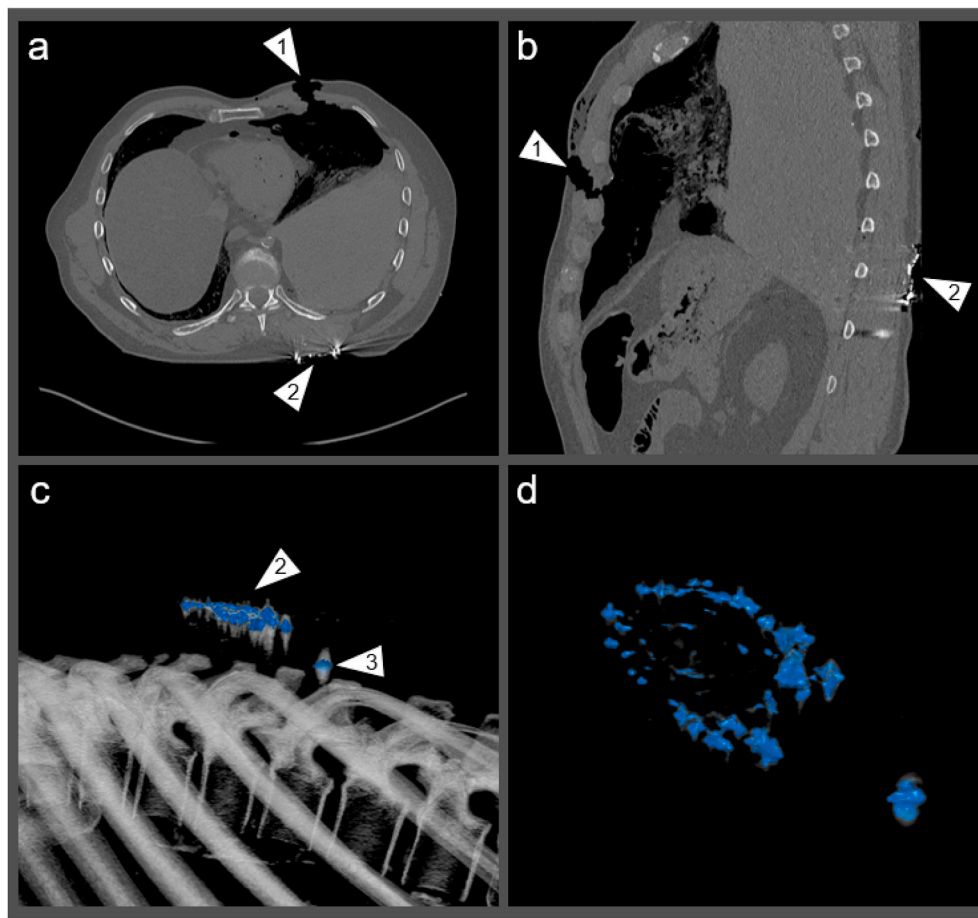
The entrance wound (arrowhead 1) and numerous bullet fragments located at the skin defect on the back of the decedent (arrowhead 2) were detected in CT-aligned multiplanar reconstructions (a: transversal view; b: sagittal view). Volume renderings (c: sagittal view; d: oblique caudocranial view) revealed an angular distribution pattern for the bullet fragments. A single fragment (arrowhead 3) was located caudal from the other fragments.
